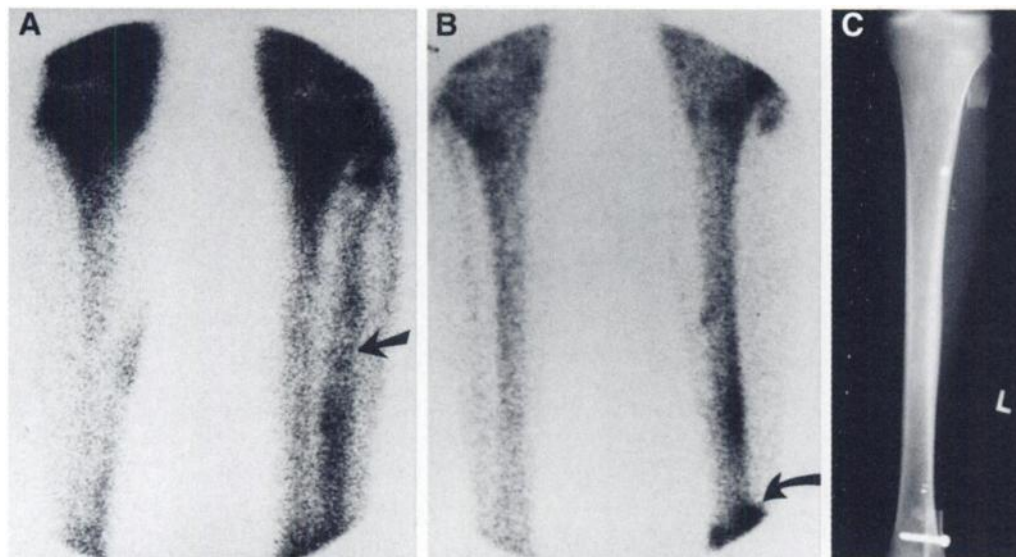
Technetium-99m skeletal scintigraphy in a 19-yr-old woman who had surgical removal of osteosarcoma of the right humerus and left fibular graft. Anterior scintigraphy of the lower legs (A) shortly after surgery revealed patchy irregular increased radiotracer activity in the left donor fibular site (arrow). One year later, on an anterior scintigram (B), radiotracer activity was absent at the site of donor fibular segment, and there was focally increased uptake at the distal tibiofibular fixation (curved arrow). The frontal radiograph (C) of the lower leg of the same patient shows the absence of the fibular segment at the donor site.
